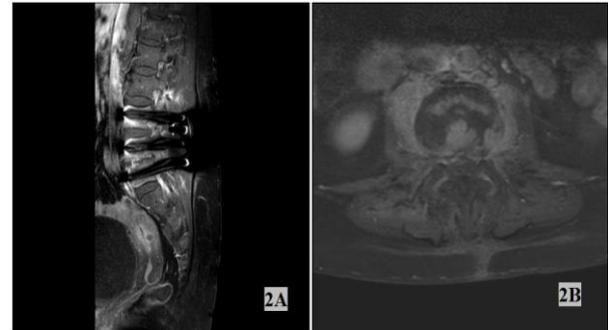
Sagittal (1A) and axial (1B) contrast-enhanced MR images showing the spondylodiscitis in a patient undergoing lumbar instrumentation
